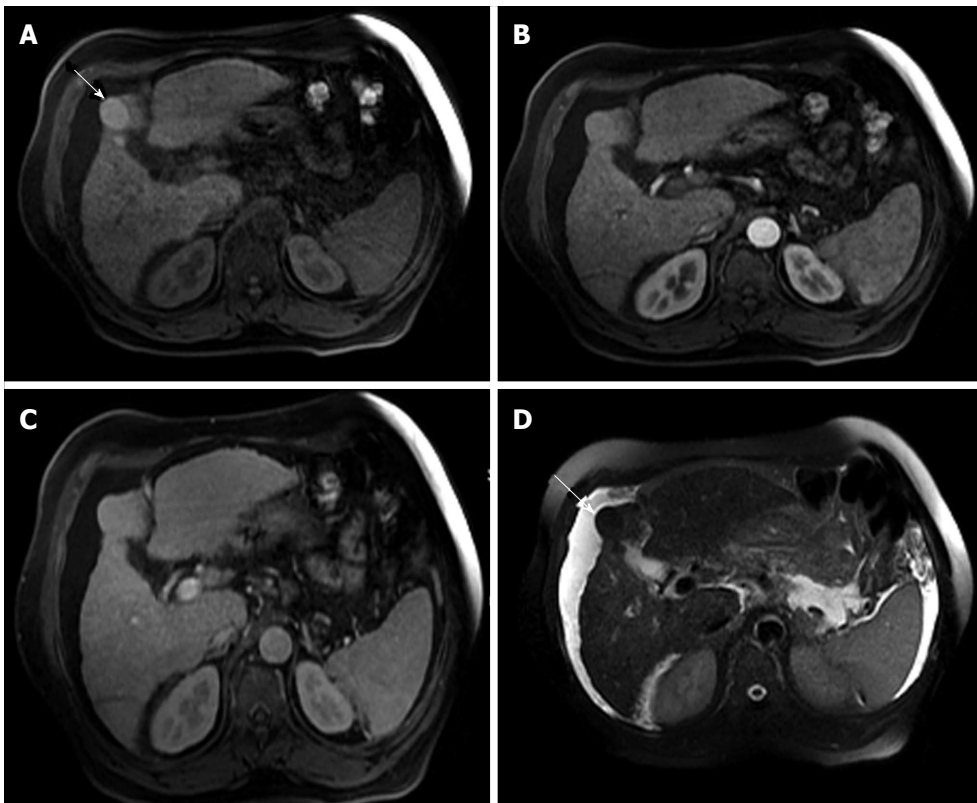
Dominant regenerative hepatic nodule. A-C: Pre- and post-contrast fat-suppressed 3D-GRE T1-weighted images during the (B) late hepatic arterial and (C) portal venous phases; D: Fat-suppressed SSFSE T2-weighted image. There is a subcapsular, partially exophytic nodule at hepatic segment #5, which demonstrates increased intrinsic T1 signal on pre-contrast images (arrow, A) and isosignal intensity to background liver parenchyma on post-contrast images (C), without appreciable increased arterial enhancement (B) or increased T2 signal intensity (arrow, D) in keeping with a dominant regenerative nodule. GRE: Gradient recalled echo; SSFSE: Single-shot fast spin-echo.
